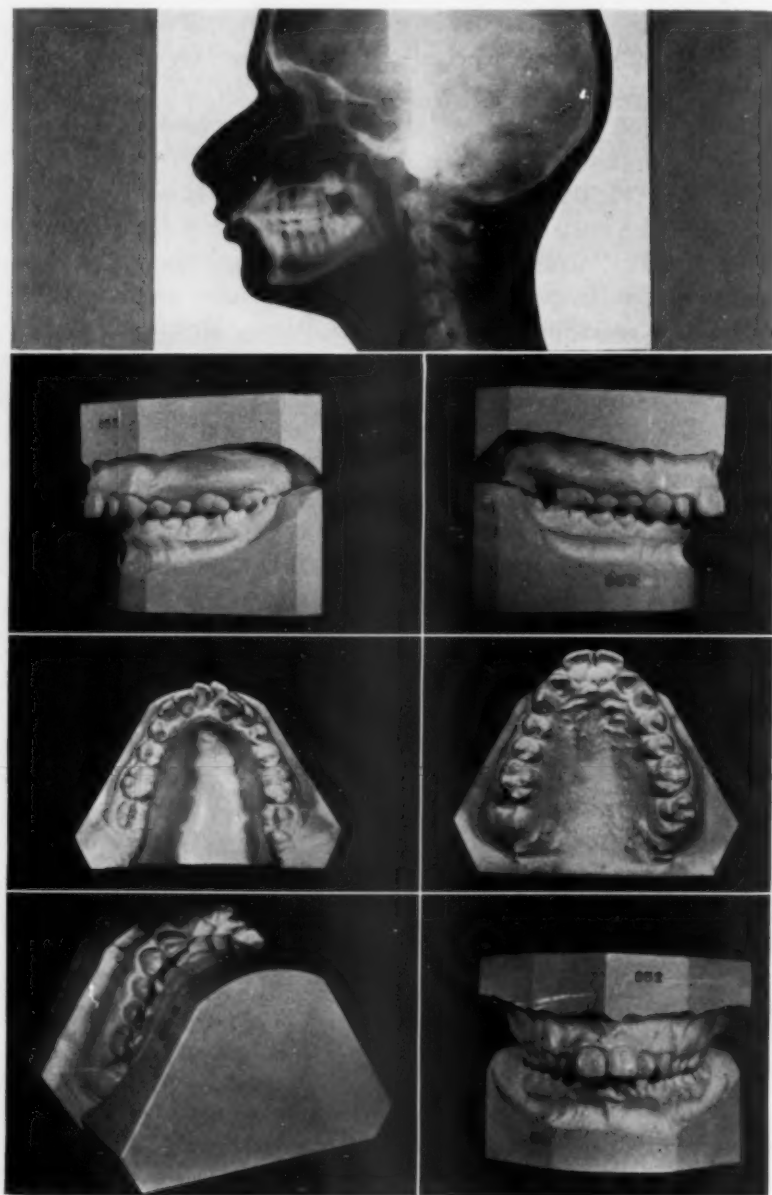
Headplate x-ray and models of a Type A, subdivision I case.
